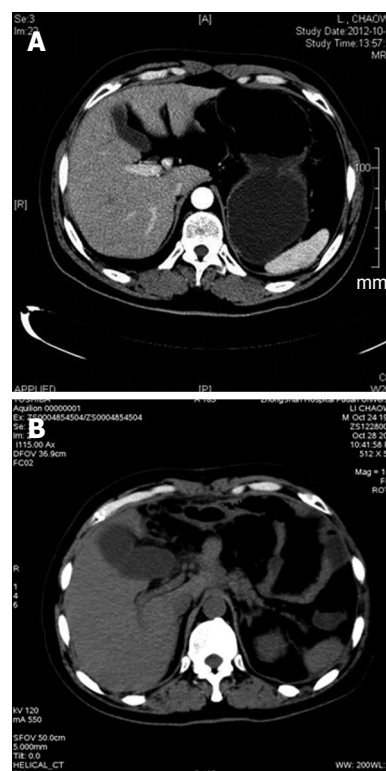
Computed tomography scan in case 1 showing normal gallbladder (A) before operation and a swelling gallbladder with thickened wall (B).
